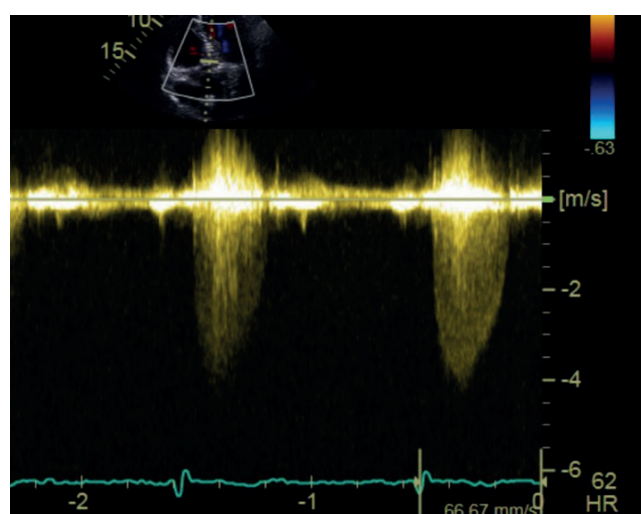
Continuous wave Doppler (CWD) from an apical five chamber window. GE M5Sc probe on Vivid S70 machine.
